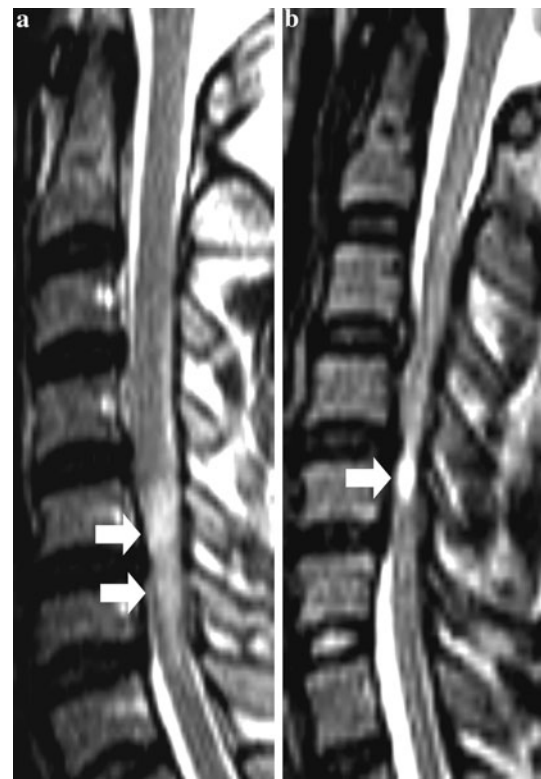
Preoperative T2W sagittal MR images showing the Q3 classification of T2W increased signal intensity (ISI). a Type 1, faint ISI with fuzzy border (arrows). b Type 2, intense ISI with well-defined border (arrow)
